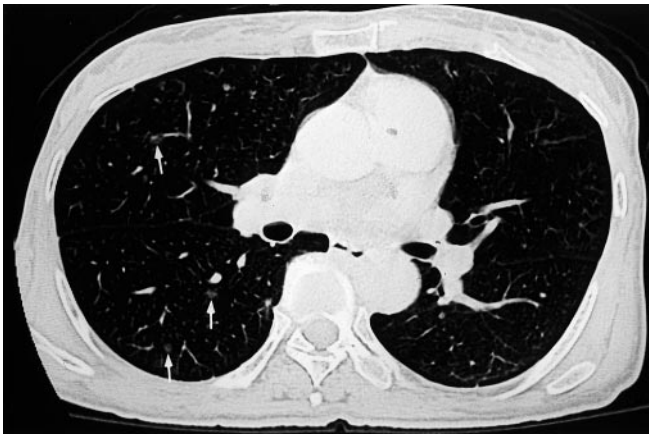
Chest computed tomography (CT) shows multiple micronodular shadows (arrows) smaller than 5 mm in diameter in the bilateral lung fields. However, cystic changes suggestive of lymph-angioleiomyomatosis (LAM) are absent
